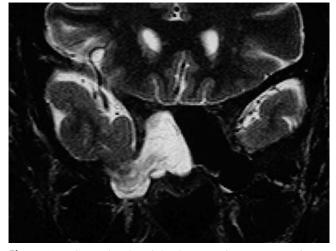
Coronal T2-weighted magnetic resonance image showing herniated brain and encephalocele into the lateral recess of the right sphenoid sinus in a spontaneous CSF leak.
